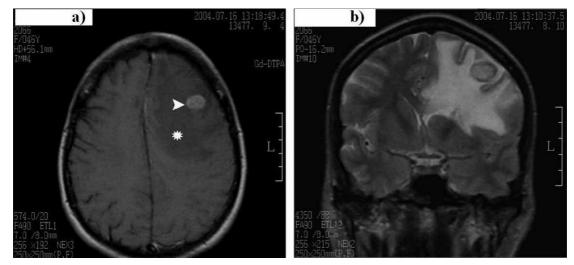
a) Brain MRI: gadolinium-enhanced T1-weighted axial image of the brain shows enhancing nodular frontoparietal lesion (arrowhead) with associated hypointense perifocal edema (asterisk); b) Coronal T2 weighted image demonstrates round lesion with intermediate signal intensity surrounded by a significant amount of hyperintense perifocal edema and mass effect to the ventricular system.
